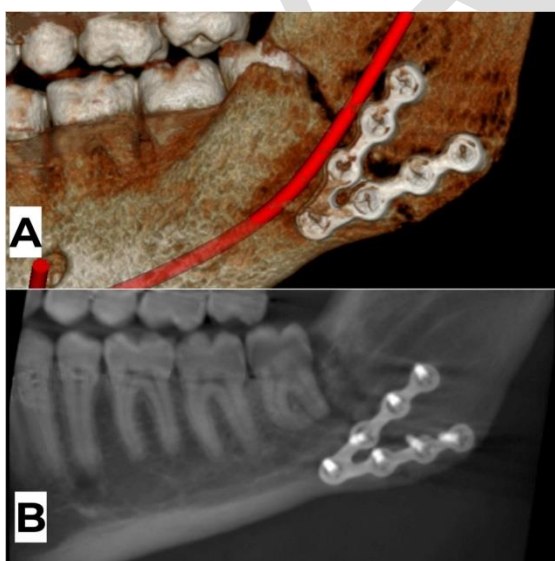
Postoperative CBCT scan for V-shaped plate: (A: 3D view - B: Panoramic view)
